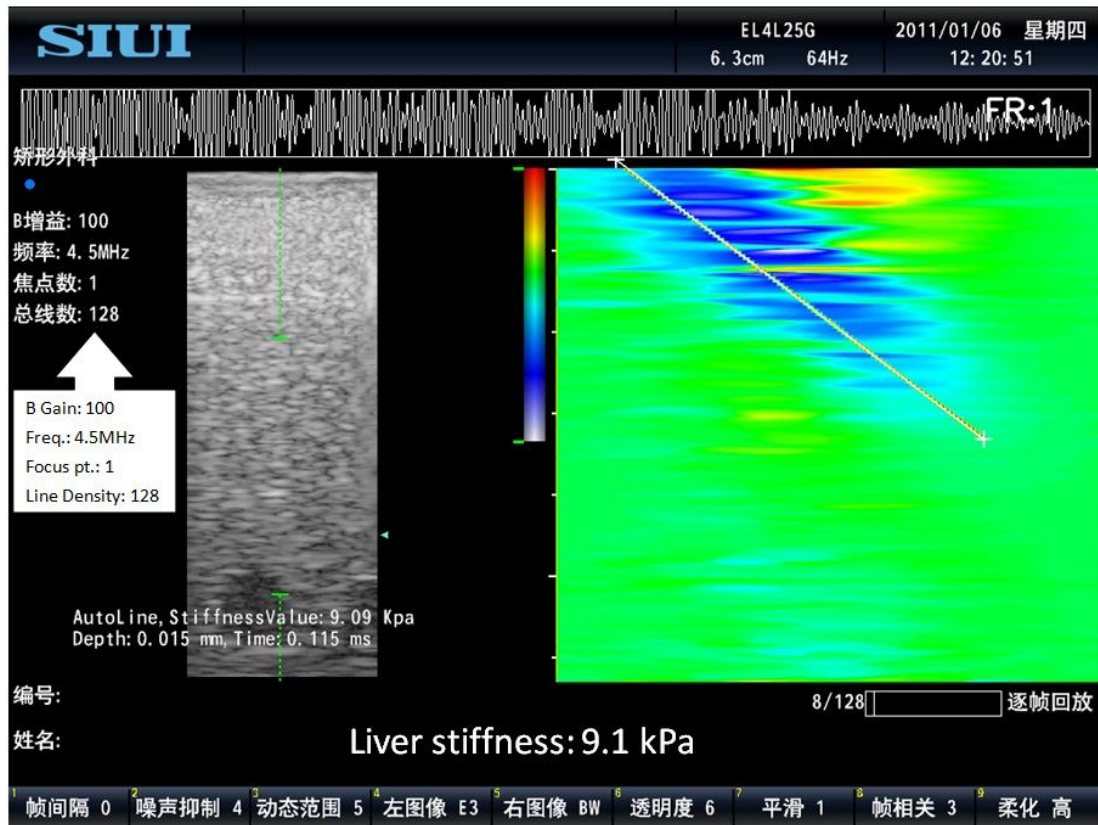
A typical measurement interface for the Liverscan. On the left, a real-time B-mode ultrasound image as guidance is provided. The elastography is displayed on the right side.
